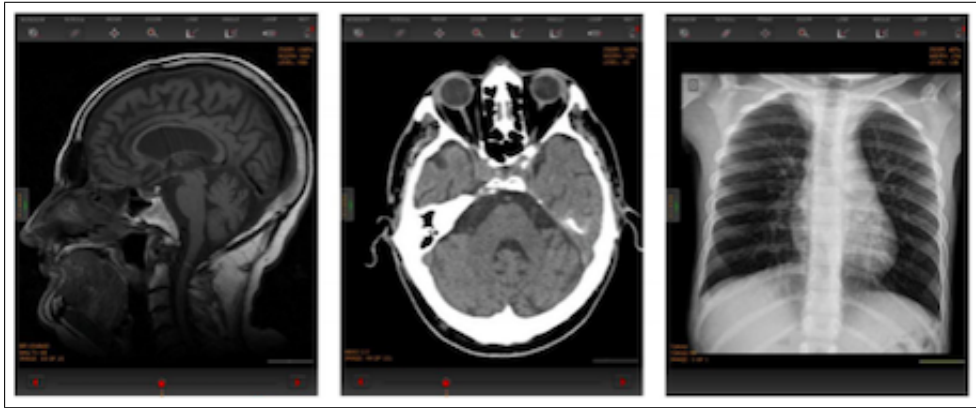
Examples of the application interface for 3 exams: MRI (left), CT (center) and conventional radiography (right).
